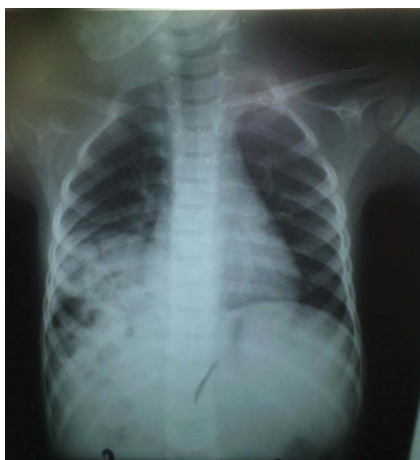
Chest radiograph showing air-filled loops of the bowel in the right hemithorax and a paucity of gas in the abdomen. The right diaphragm is not discernible.
